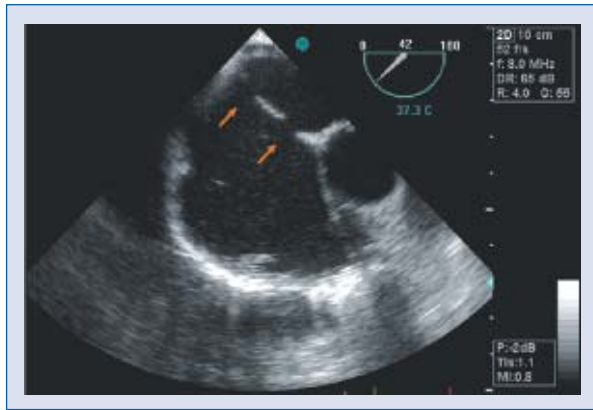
Transesophageal echocardiography revealed two different defects at the septum (arrows).
